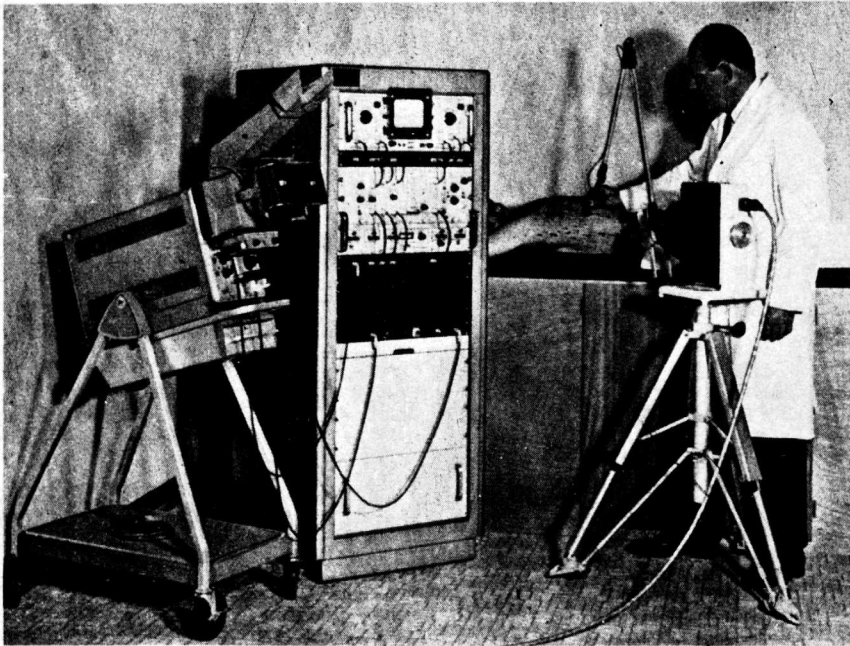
First commercial ultrasonic scanner manufactured in the United States of America. The pivot-arm scanner is mounted on a tripod at the right. The electronics and display oscilloscope are in the rack and cart at the left. The three-jointed arm scanner remains a widely utilized design concept. (Courtesy Picker Corp.)
